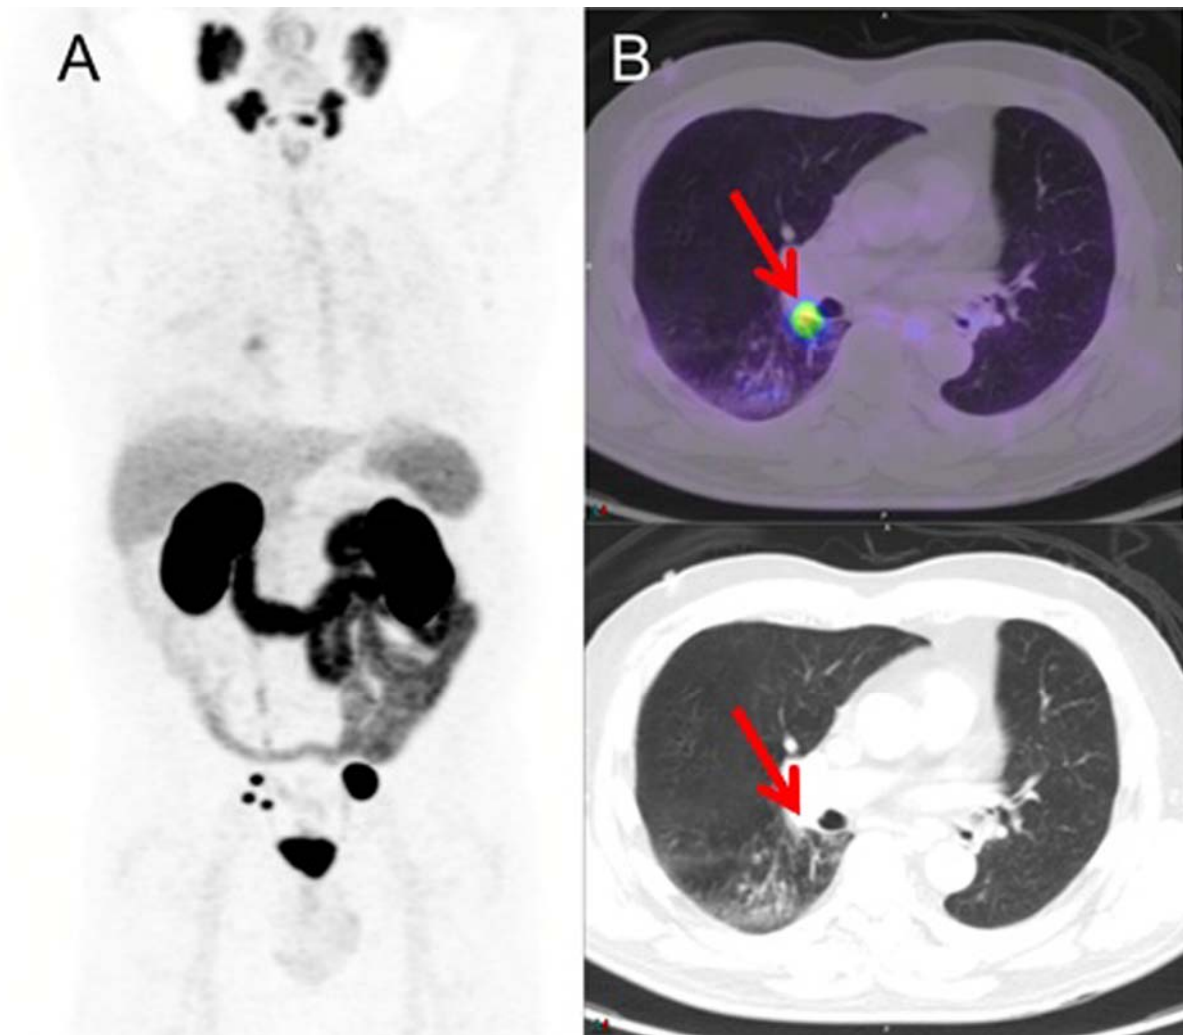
(A): MIP, (B): fused axial PET/CT and CT. Focal uptake (SUVmax 7) in a small right hilar mass on the background of more intense uptake in several pelvic nodes (SUVmax 79). Biopsy demonstrated lung adenocarcinoma.
